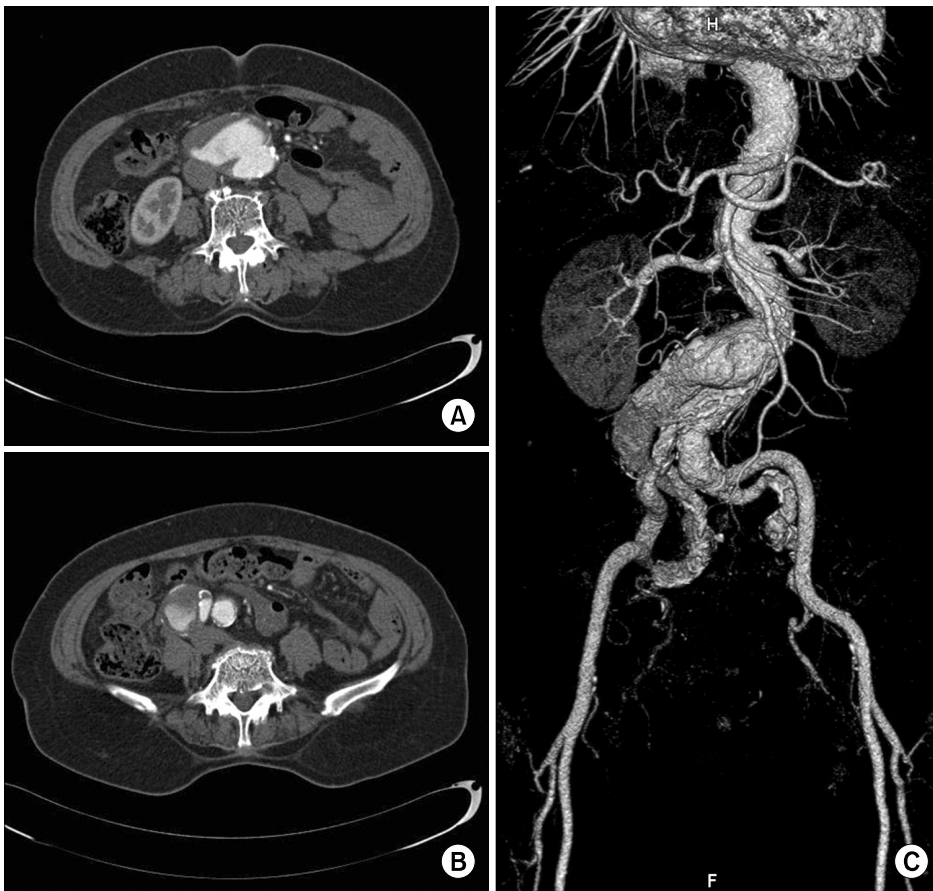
Computed tomographic angiography before endovascular aortic repair. (A, B) Computed tomographic angiography shows the infrarenal abdominal aneurysm with a maximum diameter of 50 mm and the right common iliac artery aneurysm with a maximum diameter of 36 mm in the combined chronic dissection. (C) 3-Dimensional reconstruction shows the proximal hostile neck of the infrarenal abdominal aortic aneurysm with tortuosity.
